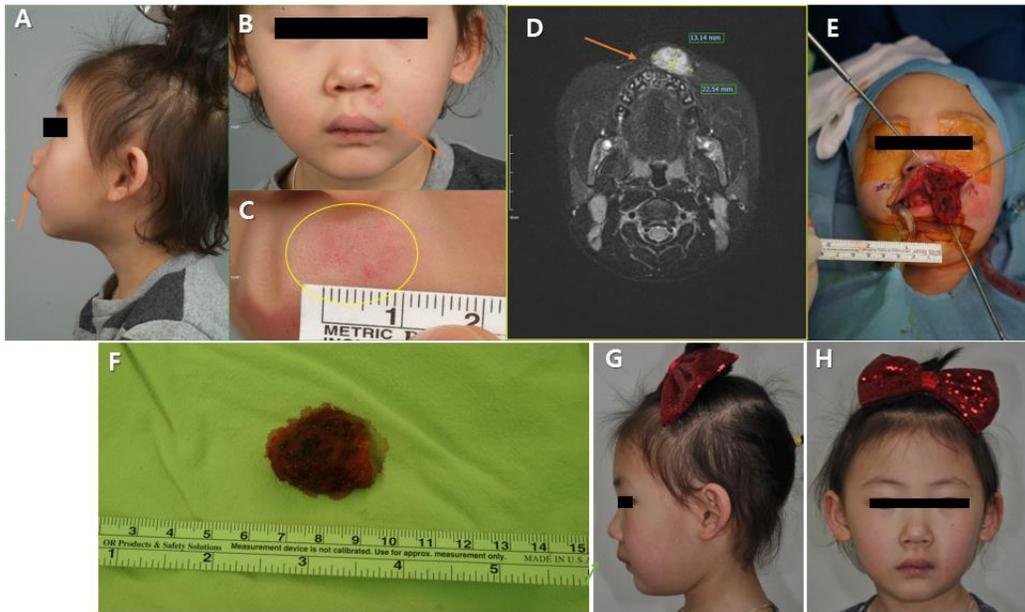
Grade 1 patient. (A), (B), (C) A patient with grade 1, upper lip, Pre-operative photograph. (D) Axial view, Hyper-intense on the MRI image. (E) Intra-operative photograph, surgery was performed with excision line. (F) Venous malformation isolated. (G), (H) Post-operative medical photograph, out clinic. Excision line was normal appearance.
